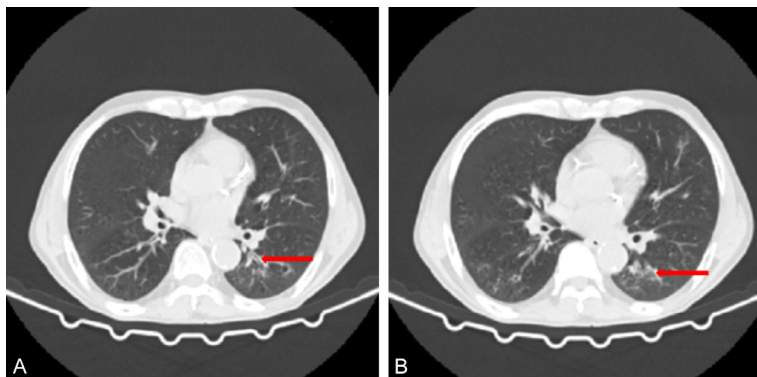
CT images of typical cases. The CT findings of lung are strip and patchy high density shadow and ground glass density shadow with blurred boundary.
